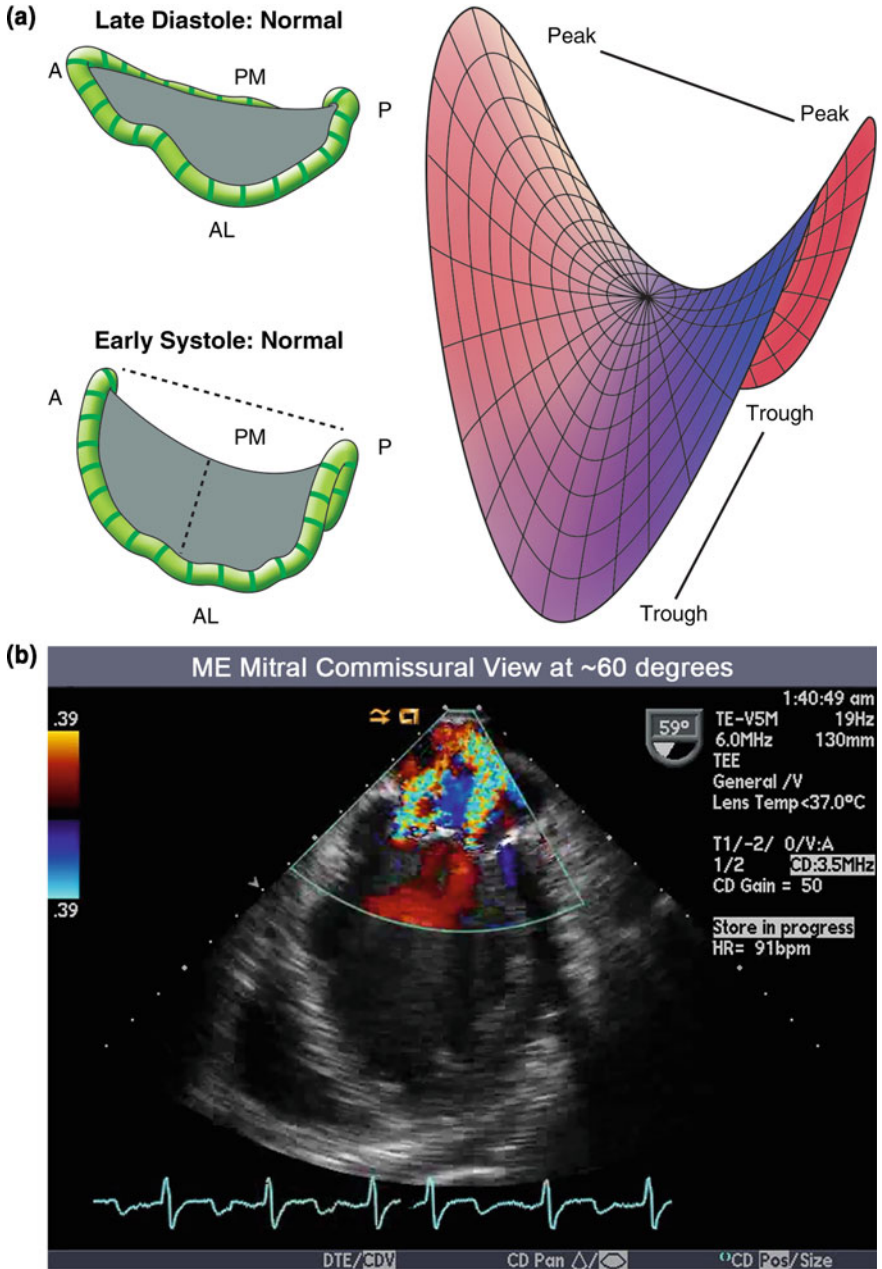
a Rendition of mitral annulus depicting the characteristic saddle-shaped geometry. The anterior–posterior axis (ME LAX view) encompasses the peak to peak distance, whereas the lateral axis (ME mitral commissural view) corresponds to the trough to trough distance. b ME mitral commissural view with color flow Doppler demonstrating two distinct jets due to a sector plane that captures the two outer edges of the jet and omitting the central portion
